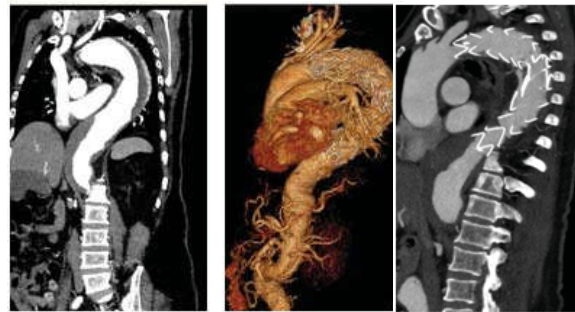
CT aortogram Type B.
